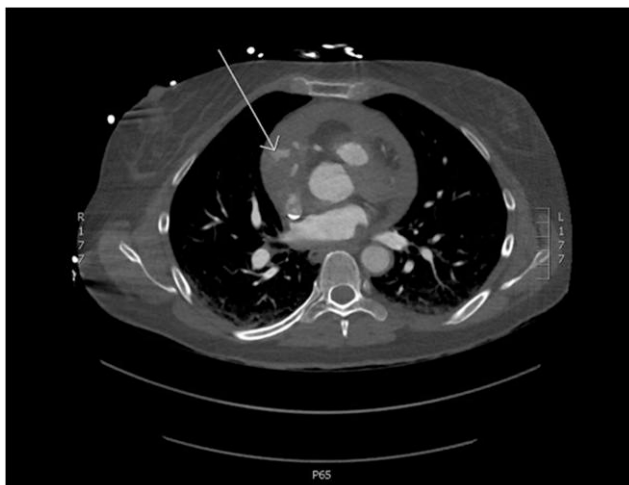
CT scan: CT aortogram showing haemopericardium with active contrast extravasation (arrow). CT, computer tomography.
